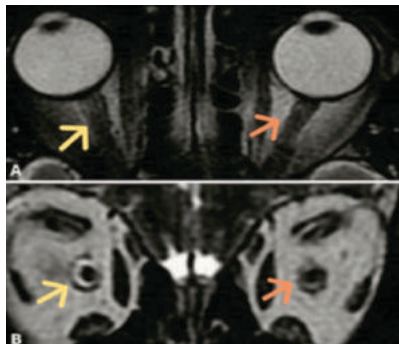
MRI Orbit images: T2 axial(a) and T2 coronal images show mild hyperintensity in bilateral optic nerves and sheath in the retrobulbar segment. (Yellow arrow: Right Optic nerve. Orange arrow: Left Optic nerve.)
